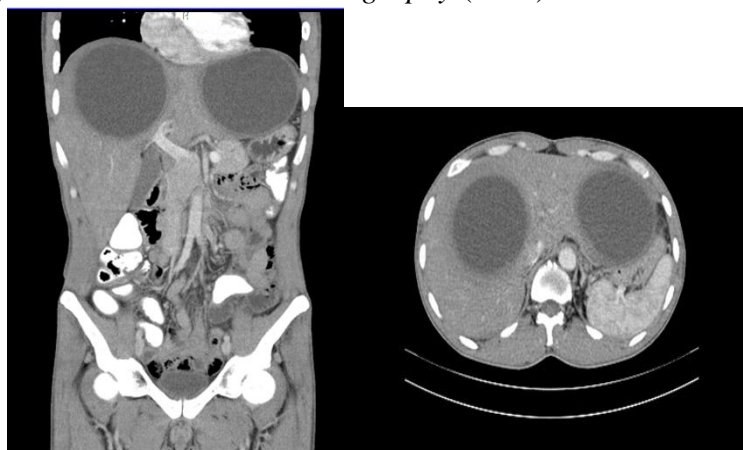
Computerized tomography* (CT) scan of the abdomen with contrast.
